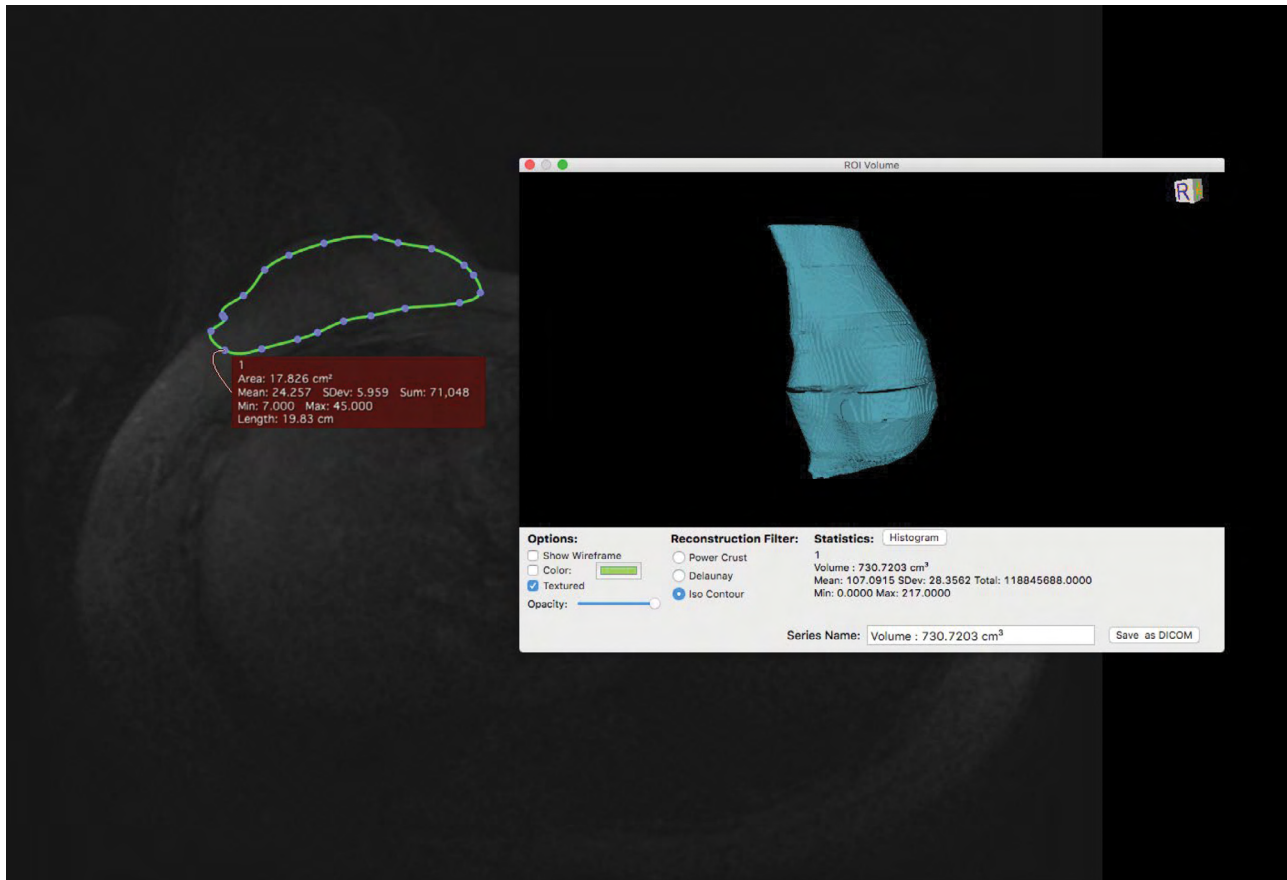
Depiction of a representative breast MRI analysis using Osirix software to reconstruct a three-dimensional model of a patient’s breast. This model is then used to obtain the volume of the breast. The left portion of the figure depicts a single MRI slice where the observer has delineated the breast borders (green tracing). After defining the borders on multiple slices, as explained in the methods, the software then creates a three-dimensional model of the breast (depicted on the right of the figure in teal) including the calculated volume.
